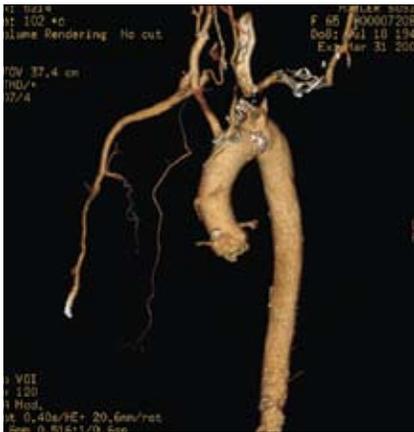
CT angiogram at 1 month showing exclusion of the ARSA aneurysm.
